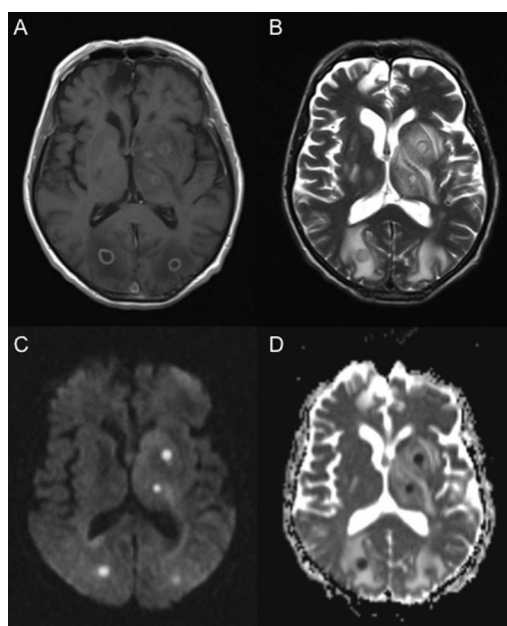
(A) Gadolinium-enhanced T1-weighted axial MRI showing multiple small ring-enhancing lesions within both cerebral hemispheres including the left basal ganglia and thalami. (B) On T2-weighted axial MRI, these lesions have high T2 signal centrally with a rim of low T2 signal and surrounding oedema. (C) The lesions have high central signal on diffusion-weighted MRI with corresponding restriction on the apparent diffusion coefficient map (D), in keeping with cerebral abscesses.
